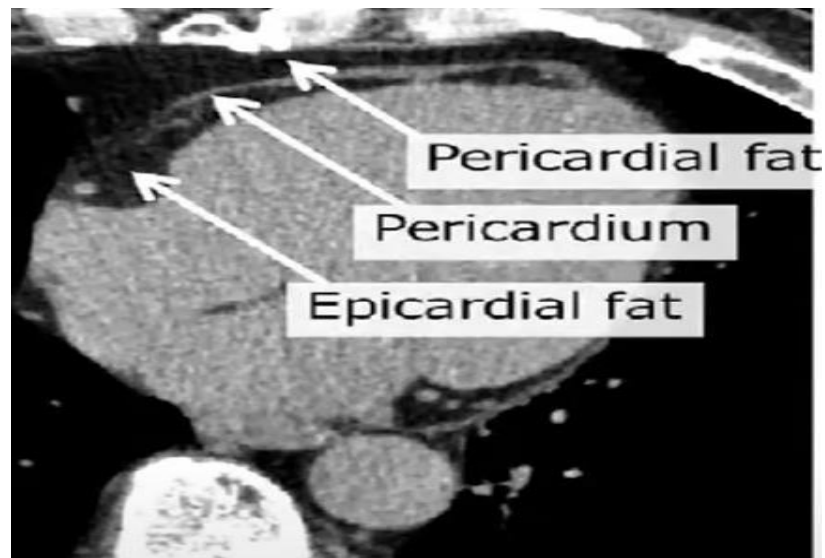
Cardiac CT view highlighting the epicardial adipose tissue, localized between the myocardium and the visceral layer of the pericardium, and the pericardial adipose tissue, localized outside the parietal pericardium.
